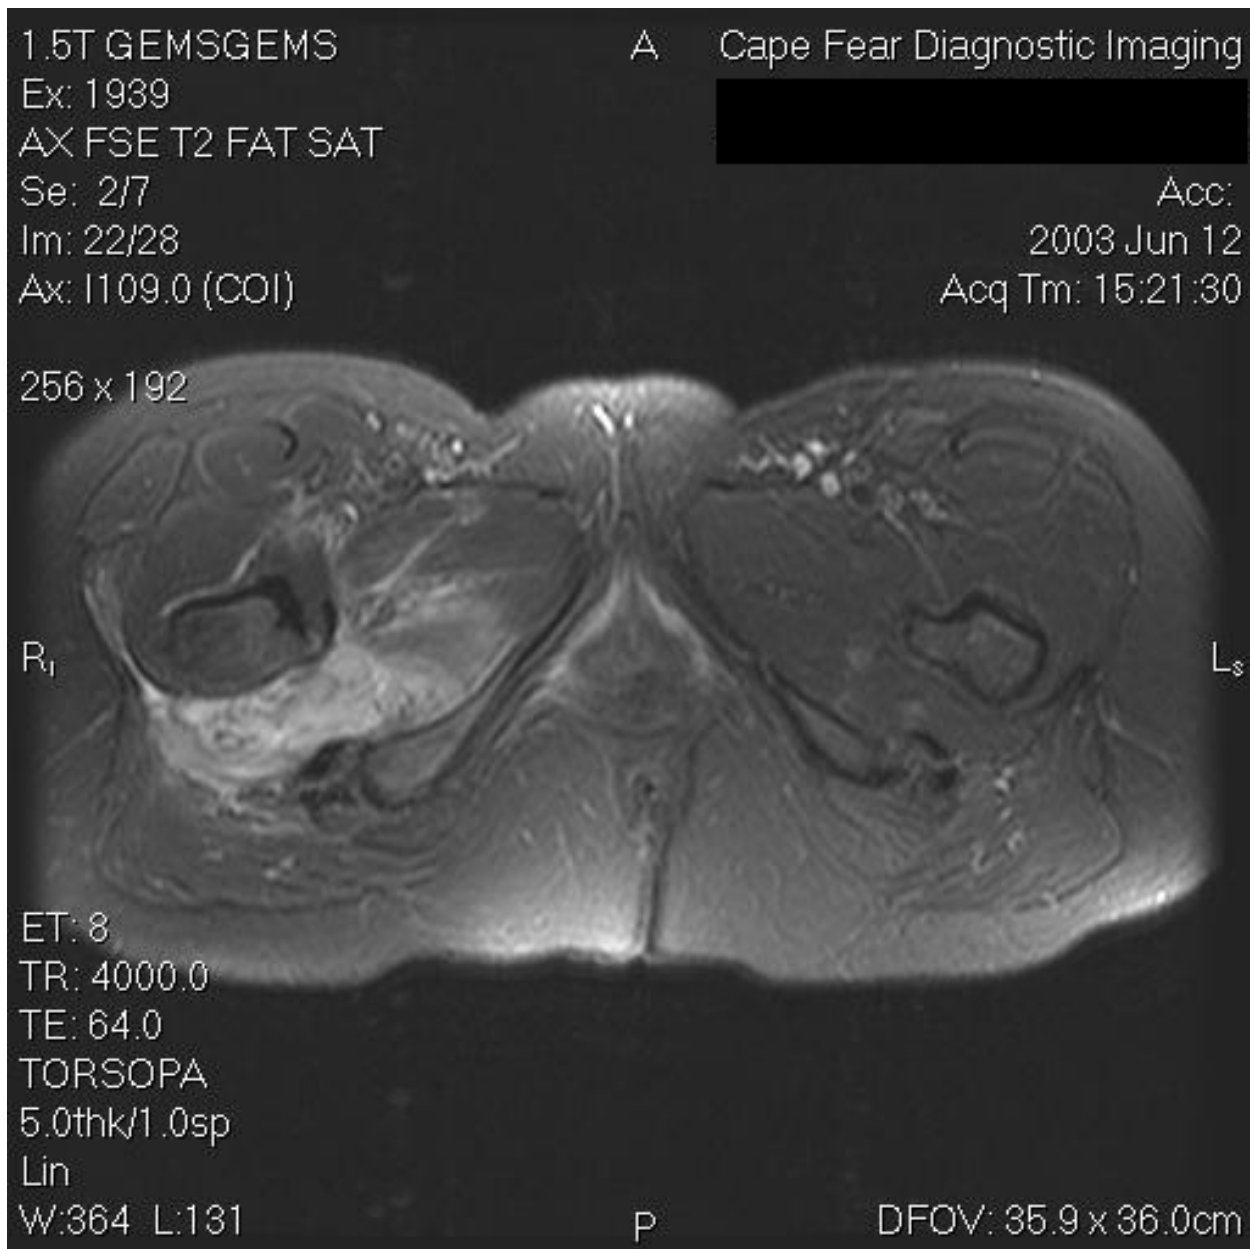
MRI – Axial T2 FAT SAT Image– Pelvis – Increased signal consistent with deep gluteal hemorrhage due to Coumadin induced coagulopathy.
